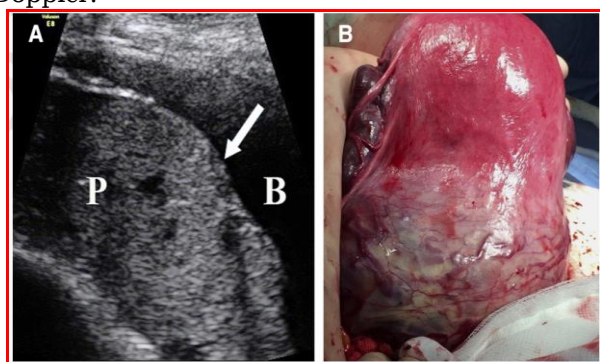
Myometrial thinning secondary to abnormally invasive placenta (P) accreta. A, Transabdominal ultrasound longitudinal view of P previa at 36 weeks showing no clear zone or myometrium detectable (arrow) between P and bladder (B). B, Findings at surgery later the same day showed neovascularization and myometrial distension over the accreta area.
